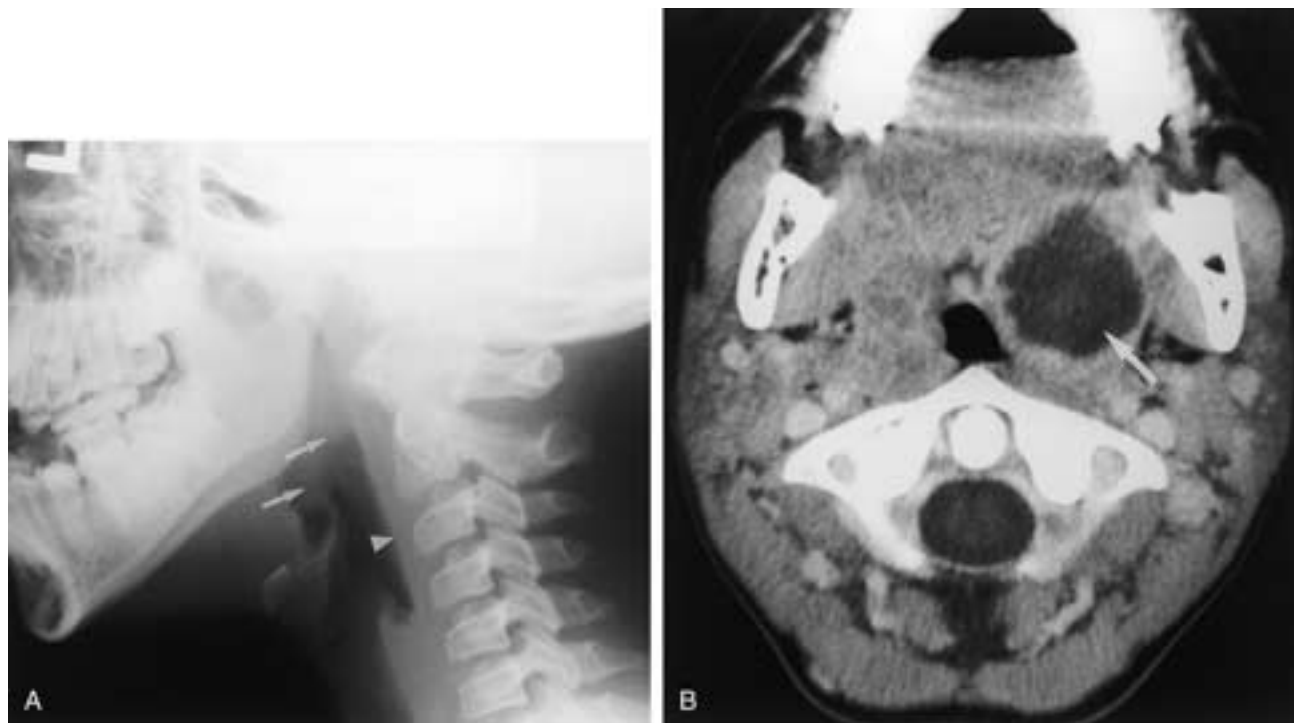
Peritonsillar abscess in a 13-year-old boy. A, Lateral plain film reveals some enlargement of the tonsils (*arrows*). Note the normal width of the retropharyngeal soft tissues (*arrowhead*). B, Contrast-enhanced CT reveals a large low-attenuation, ring-enhancing left peritonsillar abscess (*arrow*) that is distorting the airway.
